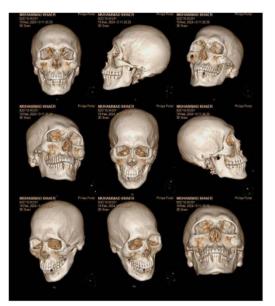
Condition of the cranium from the CT Scan photo
